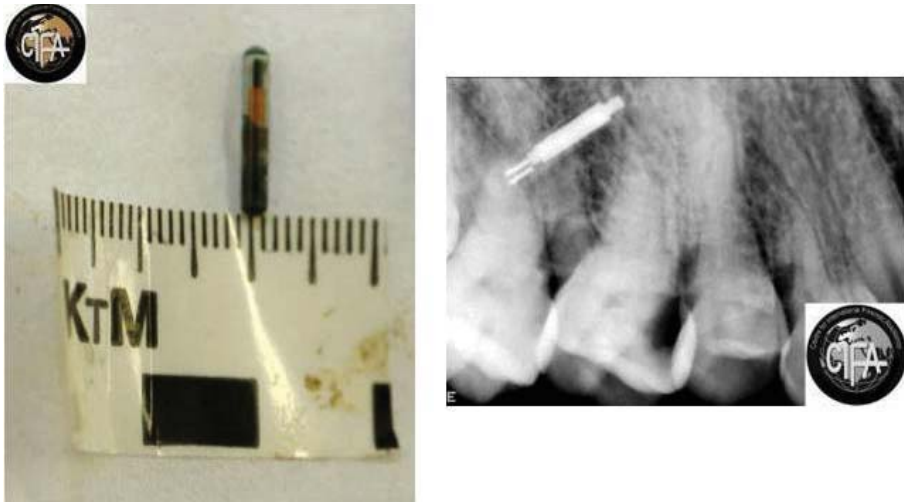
Radio-frequency ID tag used during recovery of deceased victims of the Boxing Day tsunami that hit Thailand in 2004. On the right is a radiograph of the RFID *in situ*
